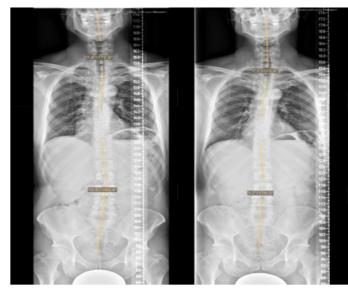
Full spine AP X-ray pre/post showing left convexity of 10.6° before and 3.7° after series of treatment. The upper thoracic region did not show any significant changes in structure.
